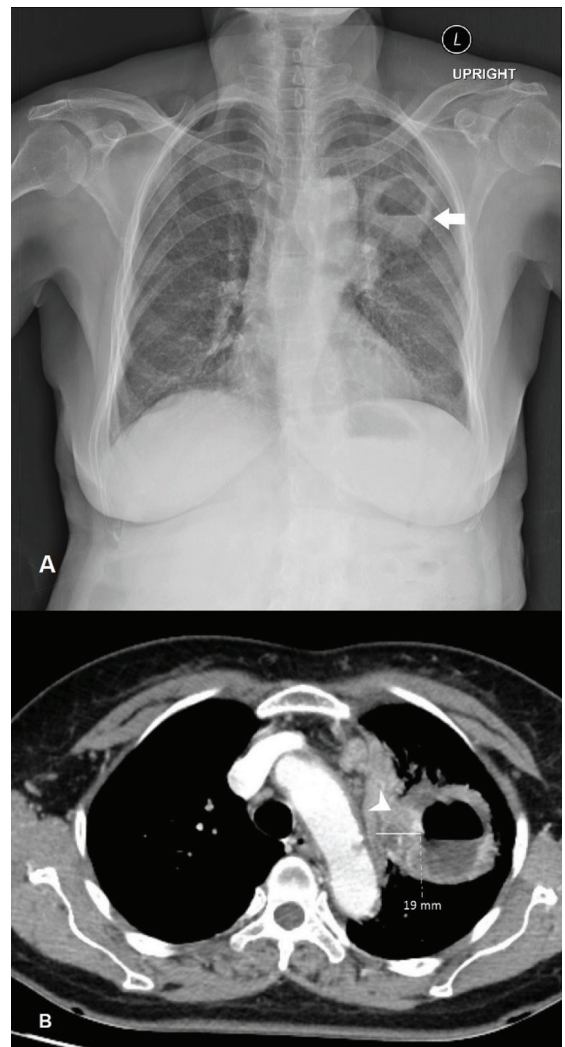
A 74-year-old woman with chronic cough for 21 days. (A) Her first chest radiograph revealed a cavity with the air-fluid level at LUL (white arrow). The visualized cavity wall measured about 9 mm in thickness, not meeting the threshold criteria for malignancy. An enlarged left hilar lymph node was also noted. (B) CT scan 39 days after the first visit showed an irregular and asymmetrical thickening wall cavity with fluid-filled at LUL. The maximal wall thickness was 19 mm, possibly obscured by the fluid on a plain radiograph (white arrowhead).
